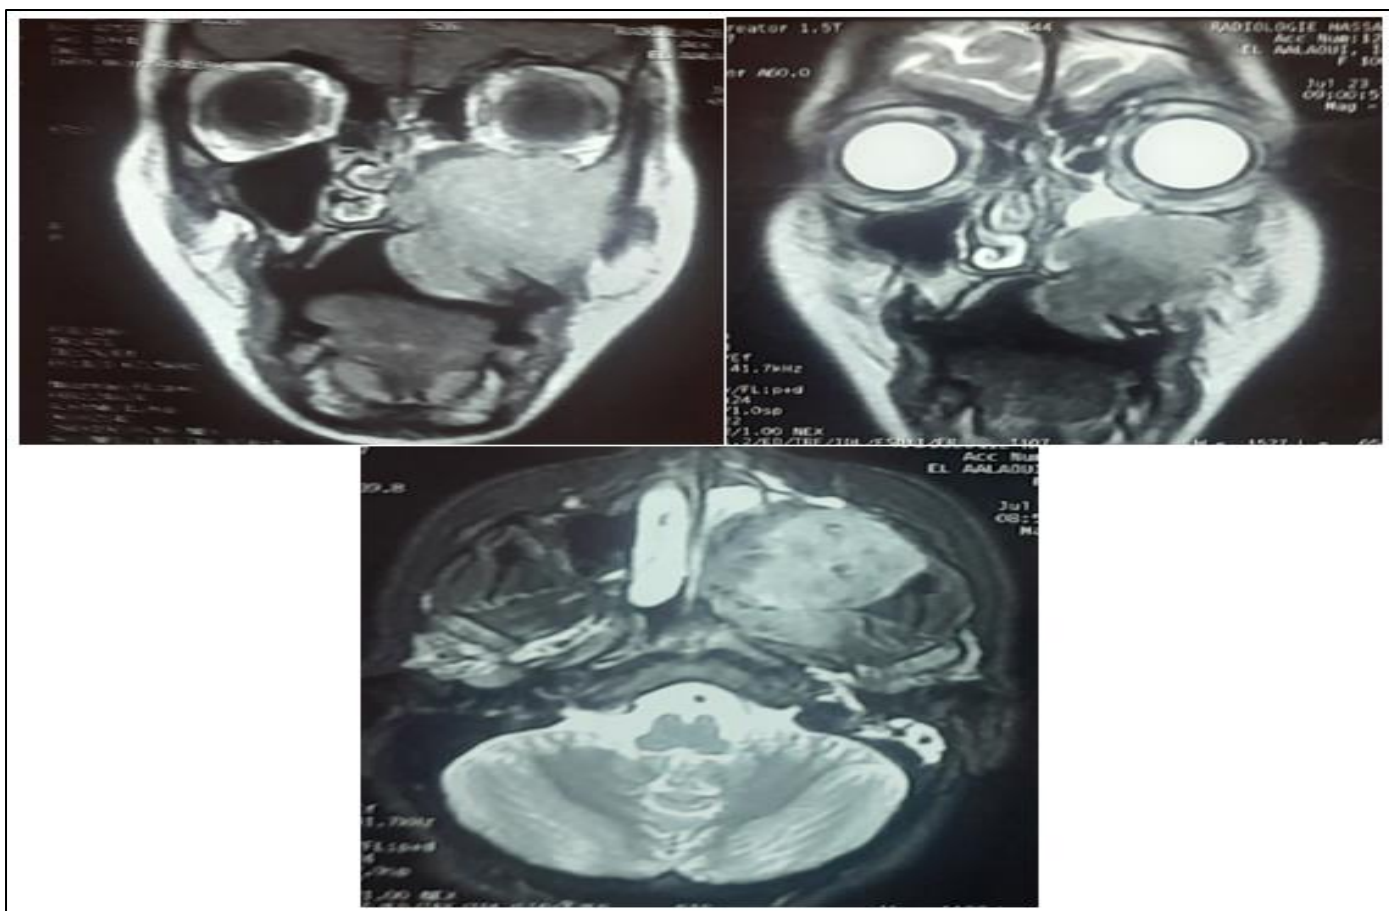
Axial and Coronal Facial MRI images showing the left maxillary sinus process in T1,T2 signal
